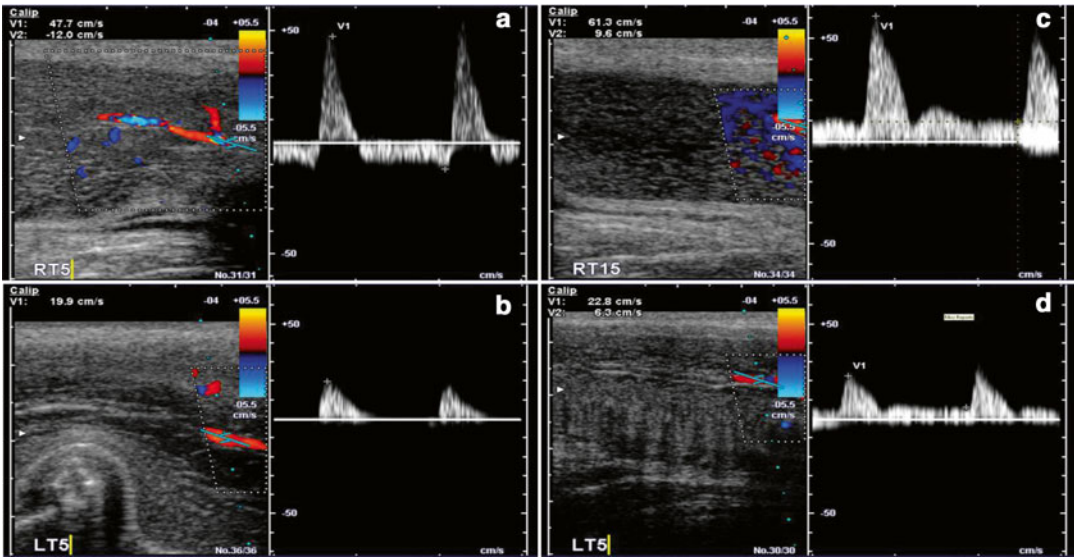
Penile duplex ultrasound evaluation of erectile dysfunction. (a) Normal penile duplex US, with peak systolic velocity (PSV) of 47.7 cm/s (V2). The *left panel* represents the US image with the Doppler measure set over an artery. The *right panel* demonstrates the vascular flow trace. (b) Arterial insufficiency, with a PSV of 19.9 cm/s
